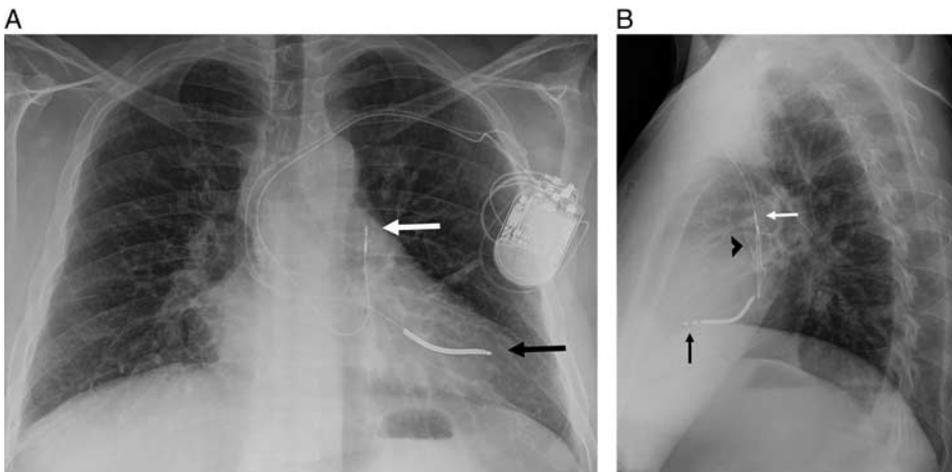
Pacemaker in patient with repaired transposition of the great arteries: frontal (A) and lateral (B) radiograph of dual-lead ICD after Mustard repair. Note the left atrial (white arrow) and LV (black arrow) lead coursing through the stented Mustard baffle (black arrowhead).
